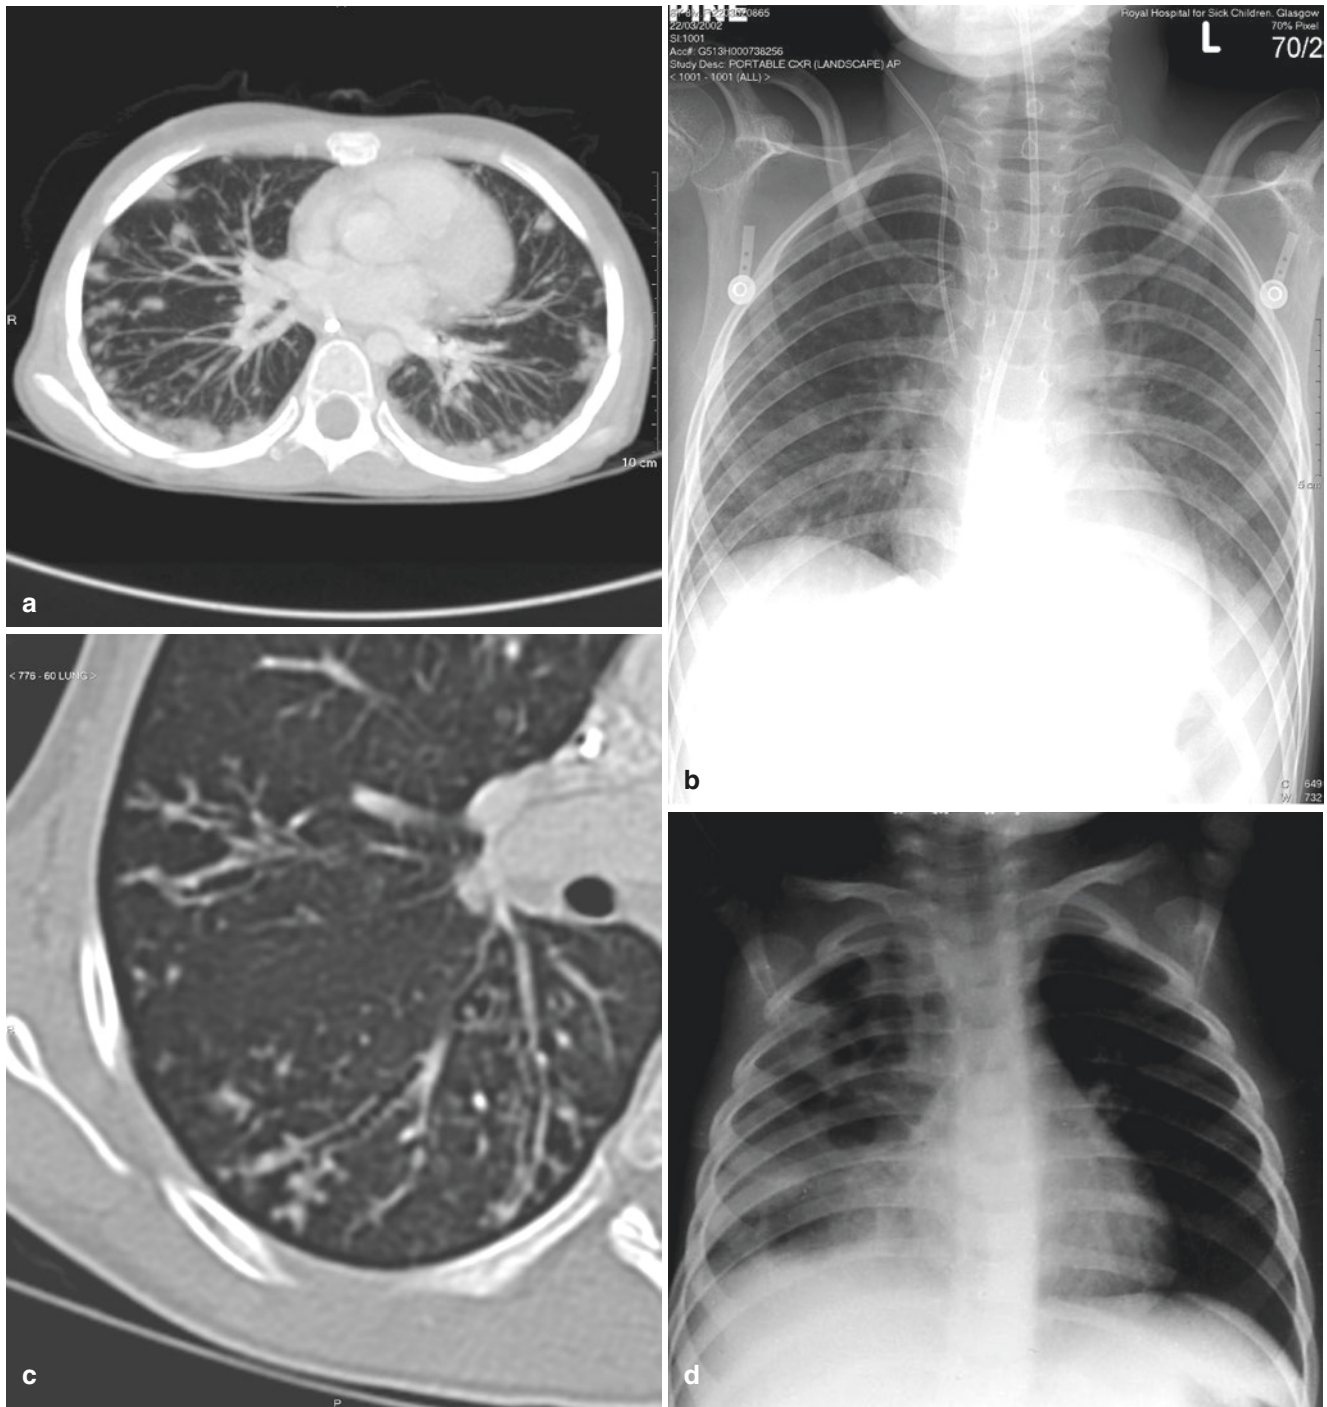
(a) CT scan of candida pneumonia. (b) Candida pneumonia. (c) Mycobacterial pneumonia. (d) Staphylococcal pneumonia
